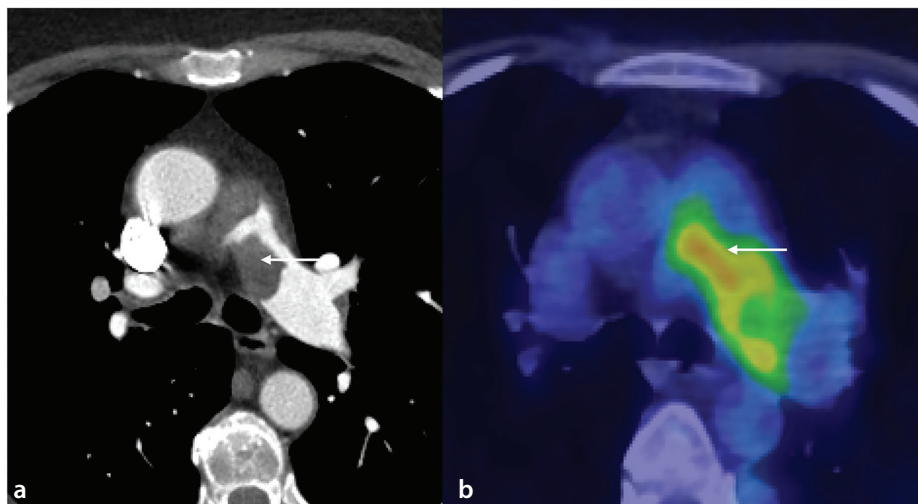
Pulmonary artery sarcoma. (a) Computed tomography pulmonary angiography image shows expansile soft tissue lesion in the main and left pulmonary arteries (thin arrow); (b) corresponding positron emission tomography/computed tomography imaging shows intense fluorodeoxyglucose avidity in the left pulmonary artery.
